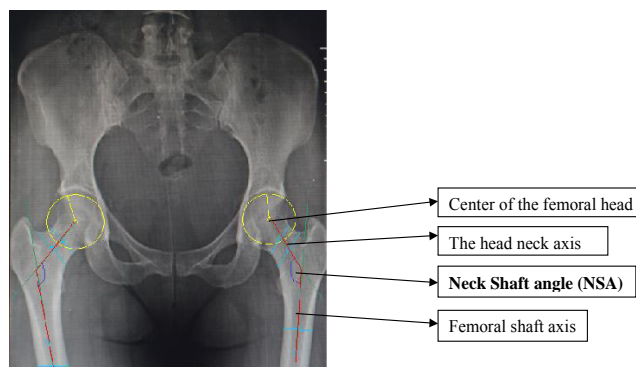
Anteroposterior radiograph of male pelvis, showing the measurement of NSA
